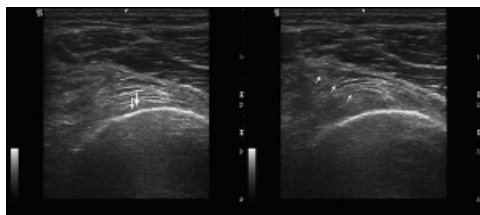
7 showing knee joint with Transverse ultrasound image of the knee at the level of the femoral medial epicondyle.⁸
